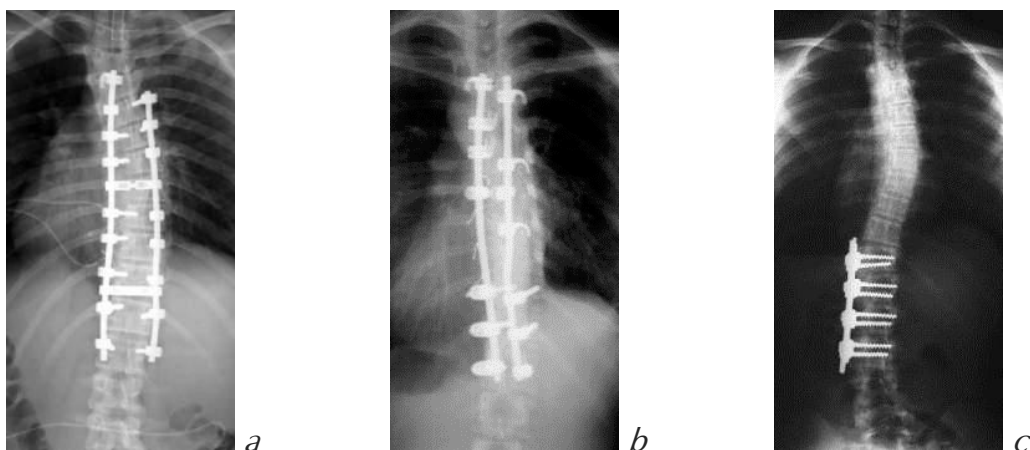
Radiographs of posterior and anterior constructs
